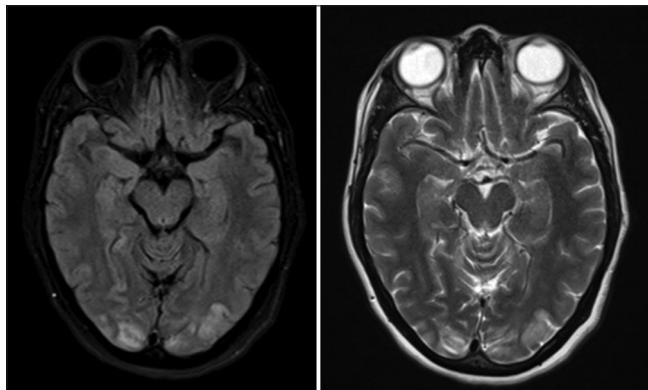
T2 and FLAIR hyperintensities in bilateral occipital regions
